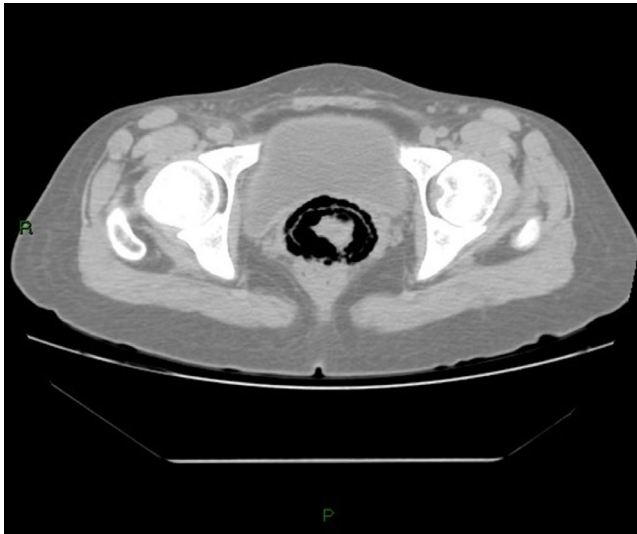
Pelvic computed tomography: We can see multiple gas-filled cysts in the vaginal wall at the level of the vaginal fornix, and the edematous cervix is seen extended into the vaginal fornix
